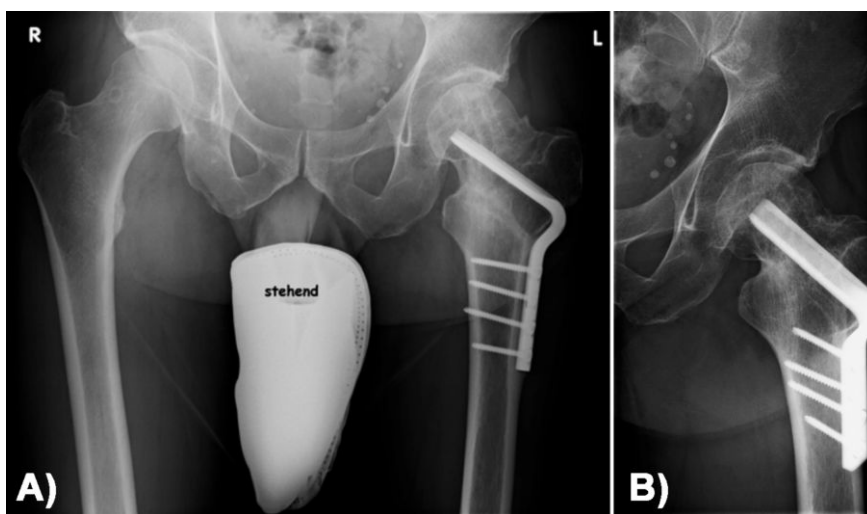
Nine-month-follow-up anteroposterior (A) and lateral (B) radiographs of the left femur show a complete union of the bone defect.
